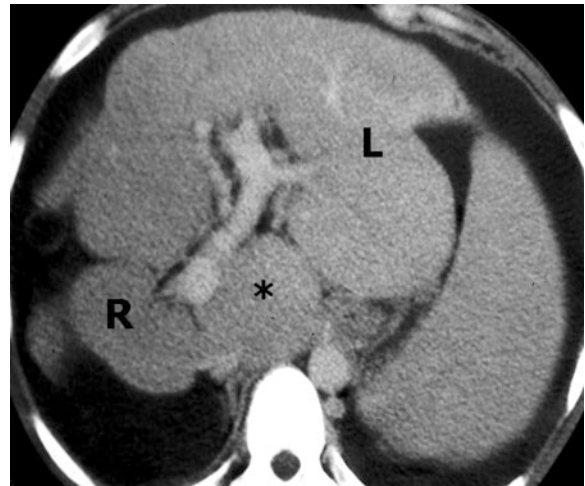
CT scans show advanced primary biliary cirrhosis in a 71-year-old woman. (a) Transverse hepatic venous phase CT scan shows morphologic changes consistent with advanced cirrhosis, with atrophy of the right hepatic lobe (R) and hypertrophy of the lateral segments of the left hepatic lobe (L) and caudate lobe (*asterisk*)
